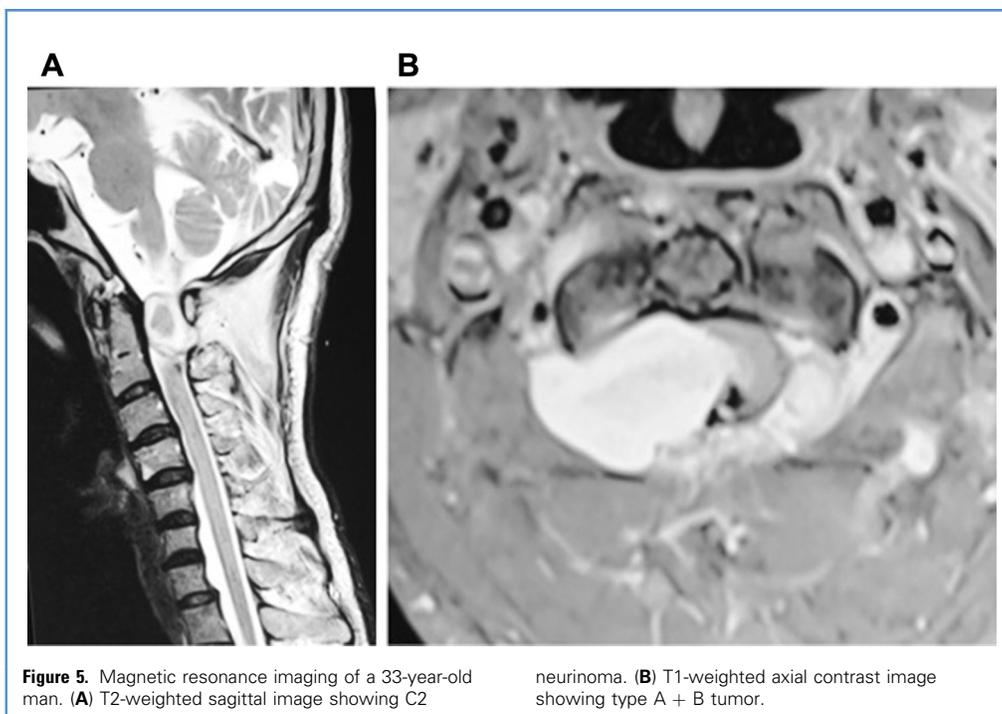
Magnetic resonance imaging of a 33-year-old man. (A) T2-weighted sagittal image showing C2
